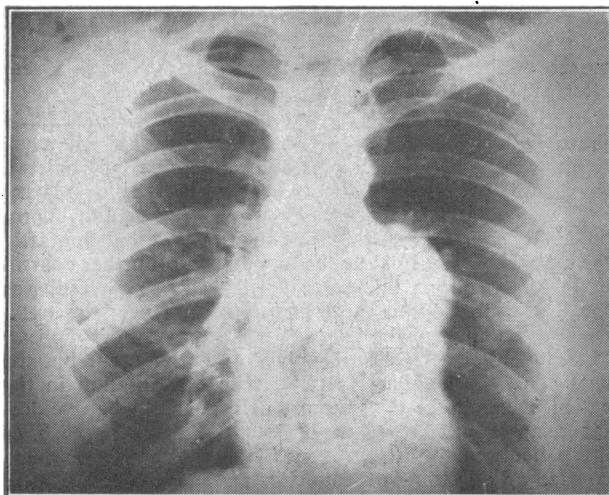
Case 1: Radiograph before treatment, showing enlarged left mediastinal lymph nodes.
